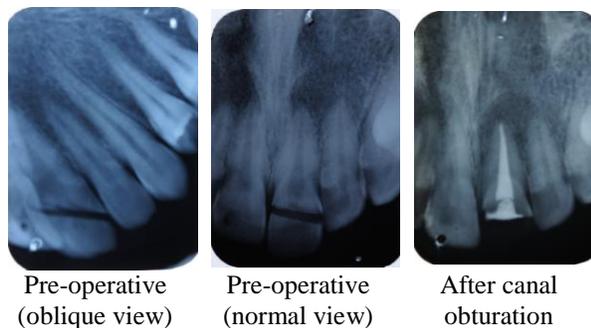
Pre-operative Per-operative Radiograph
